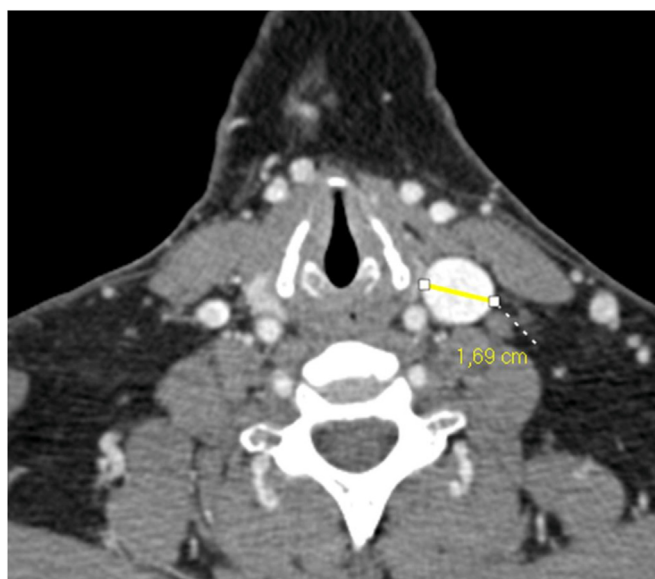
Axial computed tomography angiography (CTA) showing left internal jugular vein (IJV) ectasia with a diameter of 1.69 cm.
